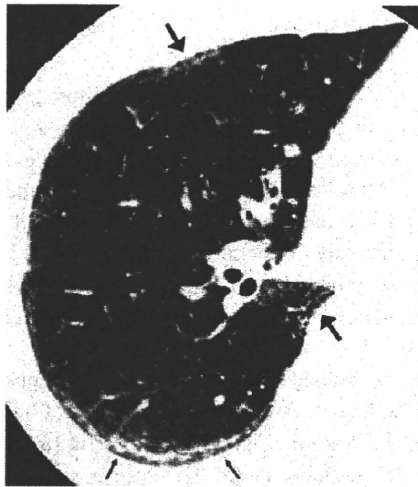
Nonspecific interstitial pneumonia (NSIP) associated with mixed connective tissue disease (MCTD) in a 45-year-old woman. Transverse thin-section CT (1-mm collimation) at the level of the right inferior pulmonary vein demonstrates intralobular reticular opacity (large arrows) with a predominantly peripheral distribution and subpleural lines (small arrows).
